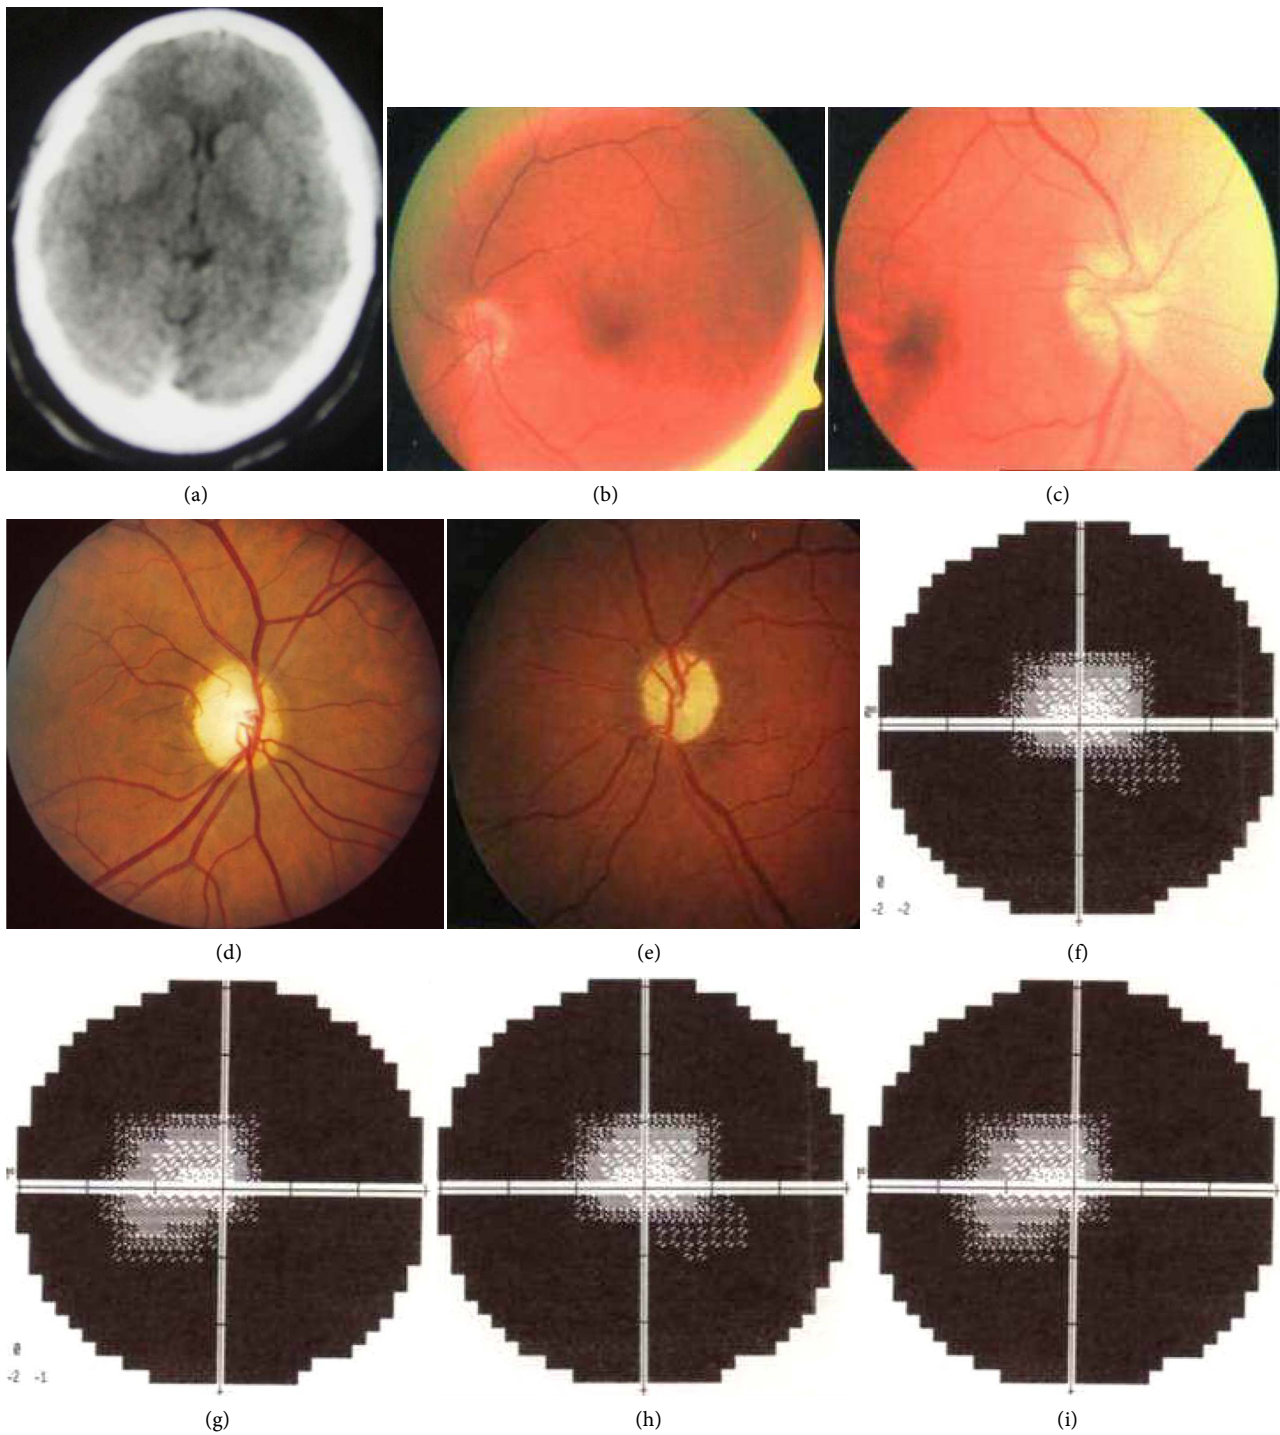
Female patient with lumboperitoneal shunt with no visual improvement, (a) Axial CT brain showed the slit ventricle, (b) and (c) Colored fundus showed chronic advanced preoperative papilledema, (d) and (e) postoperative fundus picture showed optic atrophy, (f) and (g) preoperative visual tubular field of the patient, (h) and (i) Postoperative visual field show no improvement.
